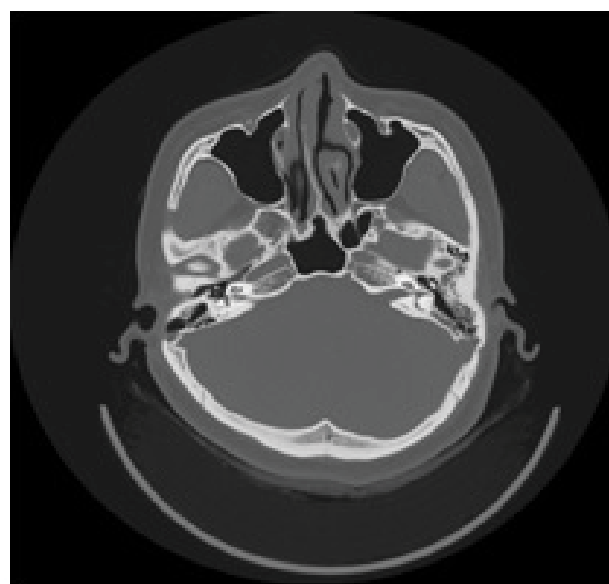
Temporal bone CT shows sigmoid sinus diverticulum of left ear and mastoid process of right ear after operation.
